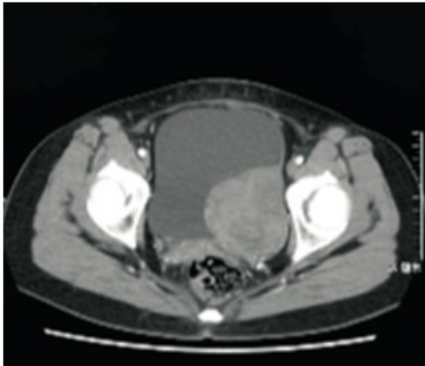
Pelvic CT: A well-defined mass was observed on the left posterior wall of the bladder, connected to the bladder wall with a broad base, about 7.3cm × 6.7cm in size, and the CT value was about 25-81HU.
